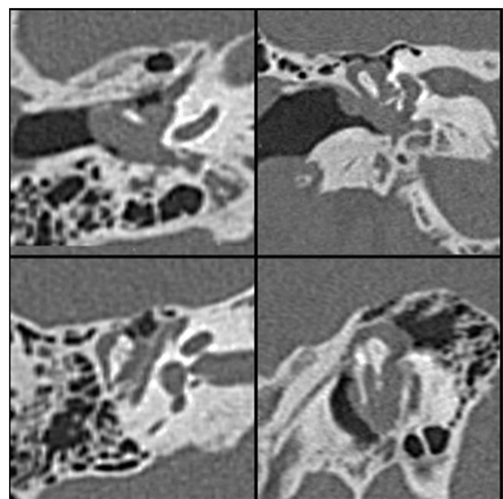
High resolution temporal CT shows a soft-tissue epitympanic mass embedded in the ossicles.
